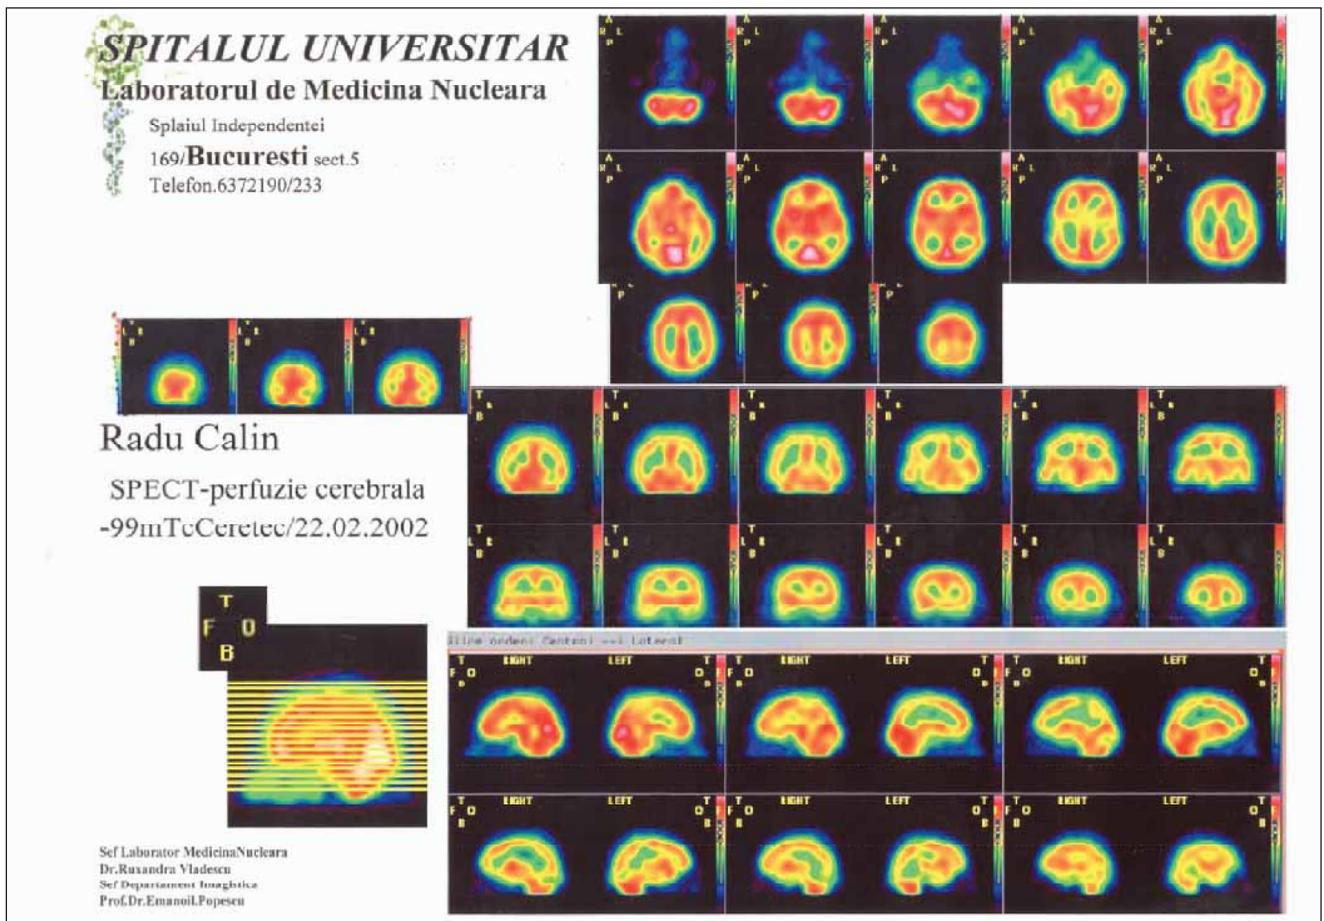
Interictal SPECT: University Hospital of Bucharest – Radiology Department: hypoperfusion area of right temporal lobe.
